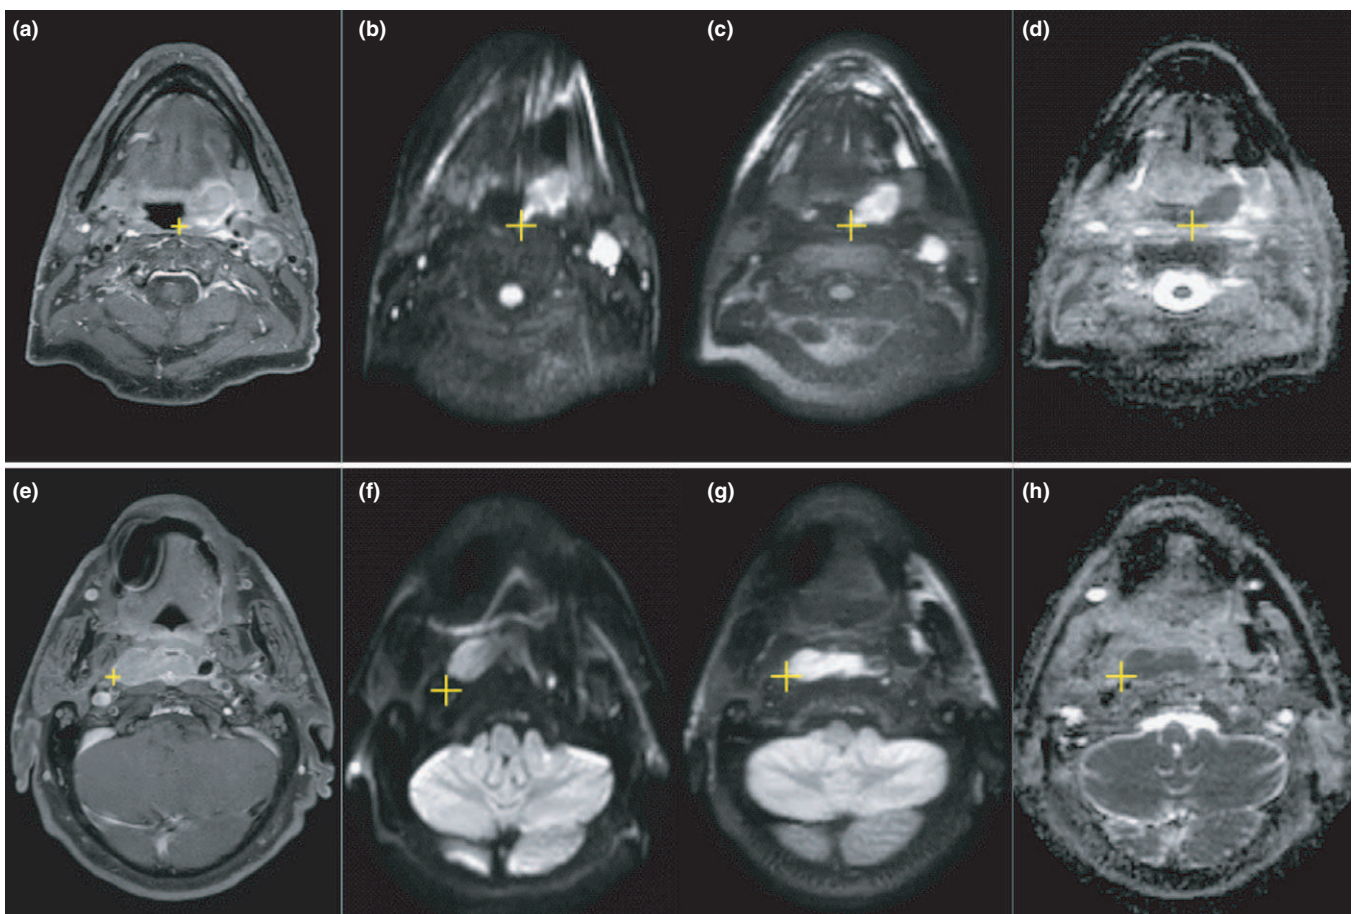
Examples of DWI in two patients, top row (a)–(d) T2N2b oropharynx, bottom row (e)–(h) T1N0 nasopharynx (with a dental implant causing a signal void). The cursor is linked between different MR scans of the same patient. (a), (e) T1 TSE Dixon, water image, with Gd contrast. (b), (f) DW-EPI b800. (c), (g) DW-SPLICE b800. (d), (h) DW-SPLICE ADC map. [Color figure can be viewed at wileyonlinelibrary.com]
